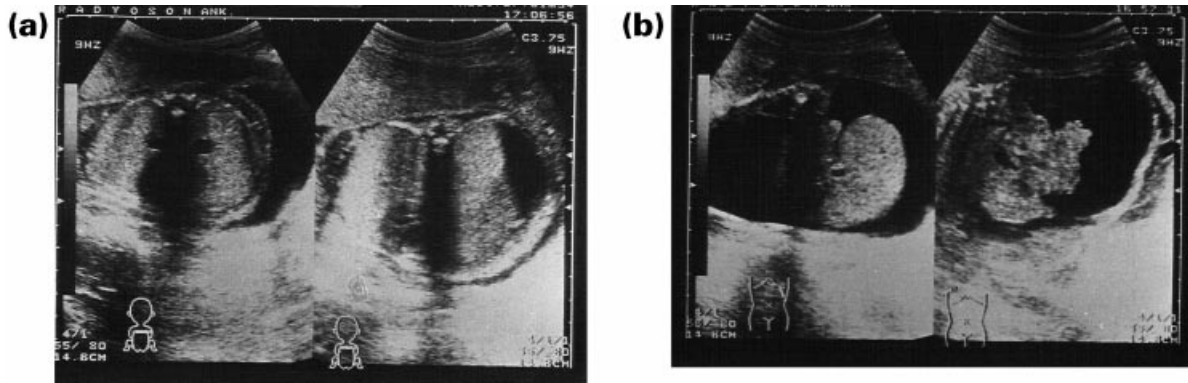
(a) Bilateral hyperechogenic lung fields, similar in appearance to type III CAM, were noted on 25-week-old fetal ultrasonography. (b) Fetal ascites and oligohydramnios were detected on 25-week-old fetal ultrasonography
